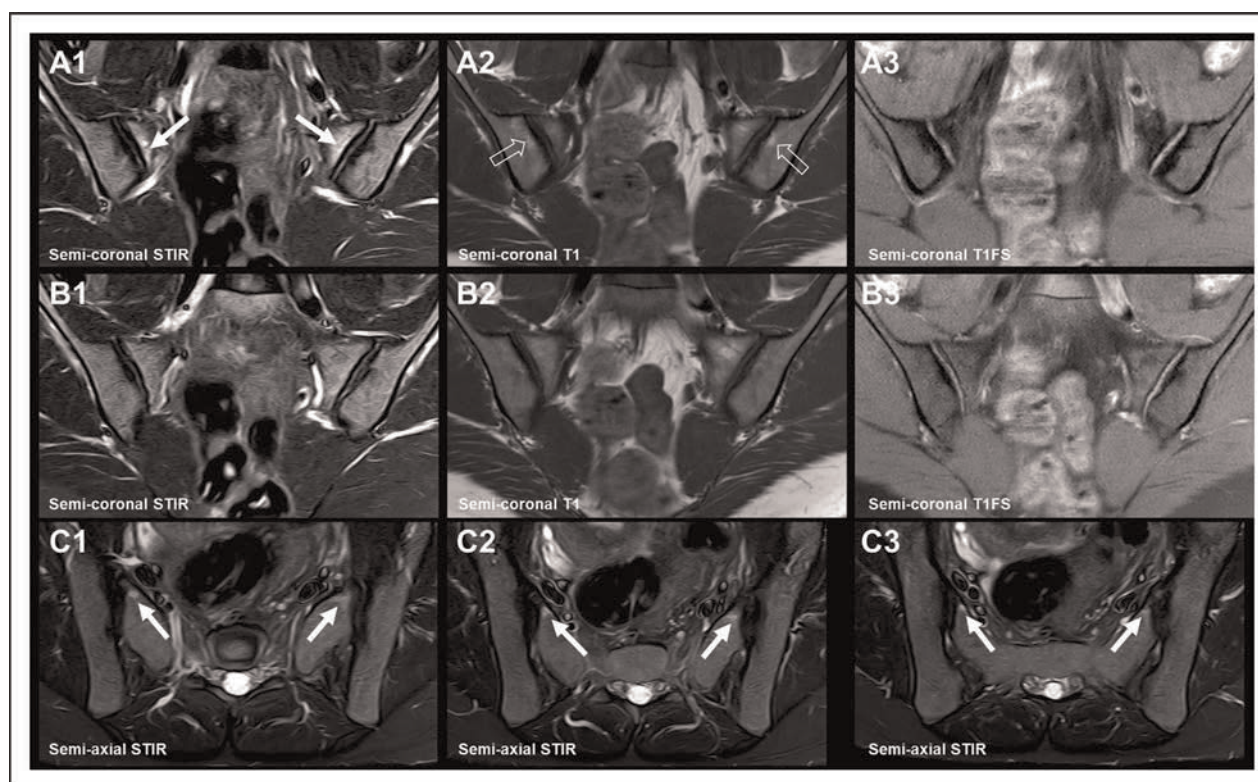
Load-related bone marrow edema and fat lesions. MRI in a 29-year-old woman with a BMI of 25 kg/m² and buttock pain starting after a twin pregnancy with delivery 18 months previously, but no clinical or biochemical findings suggesting sacroiliitis. Two consecutive semi-coronal STIR (a1, b1) and corresponding T1-weighted (a2, b2) and T1FS images (a3, b3) anteriorly in the joints and consecutive semi-axial STIR images at the upper and middle part of the joints (c1, c2, c3). There is symmetrical subchondral BME anteriorly in the sacrum on both sides (arrows on a1, c1, c2, c3) with concomitant fat lesions anterior/superior in the ilium (open arrows on a2), but no erosions (a3, b3). BME, bone marrow edema; SIJ, sacroiliac joint; STIR, Short Tau Inversion Recovery; T1FS, T1 fat suppressed.
